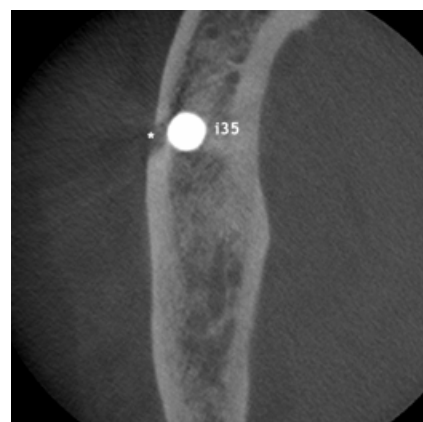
Axial CBCT image
